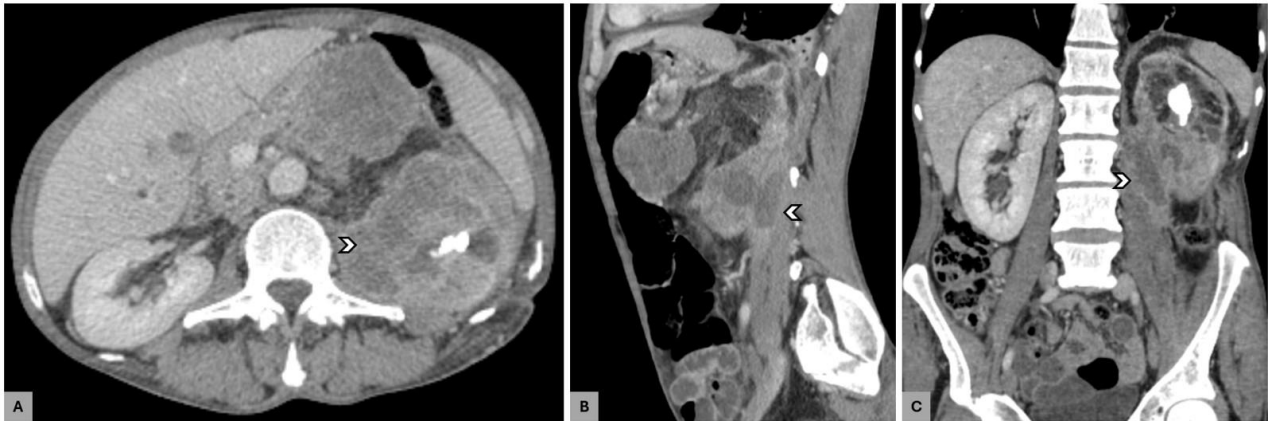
Follow-up contrast-enhanced computed tomography performed one year later showing an ill-defined infiltrative mass in the lower pole of the left kidney with heterogenous enhancement and central necrosis (white arrow head). The lesion extends beyond the renal capsule into the perirenal and posterior pararenal spaces, with involvement of the psoas muscle.
